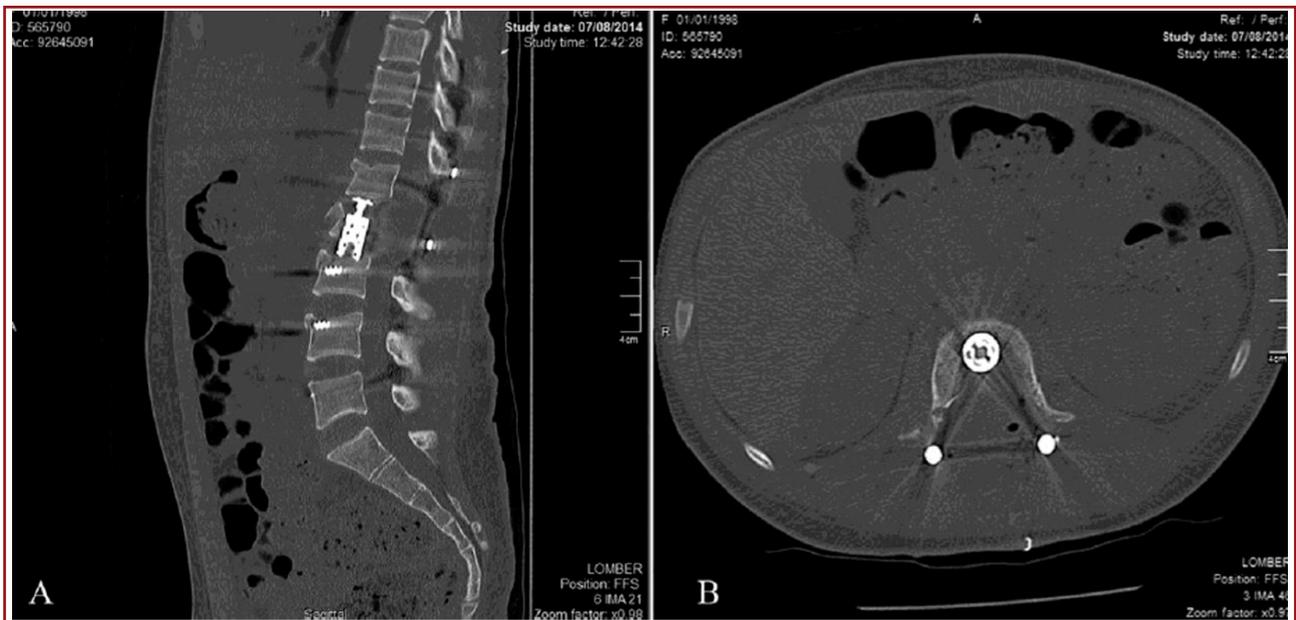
A,B. On sagittal and axial CT images, there are posterior instrumentation materials from L5 vertebra to T11 vertebra. On axial images the right pedicle of L2 vertebra is not seen due to operation. There are no bone fragments in the spinal canal and no spondylolisthesis.
